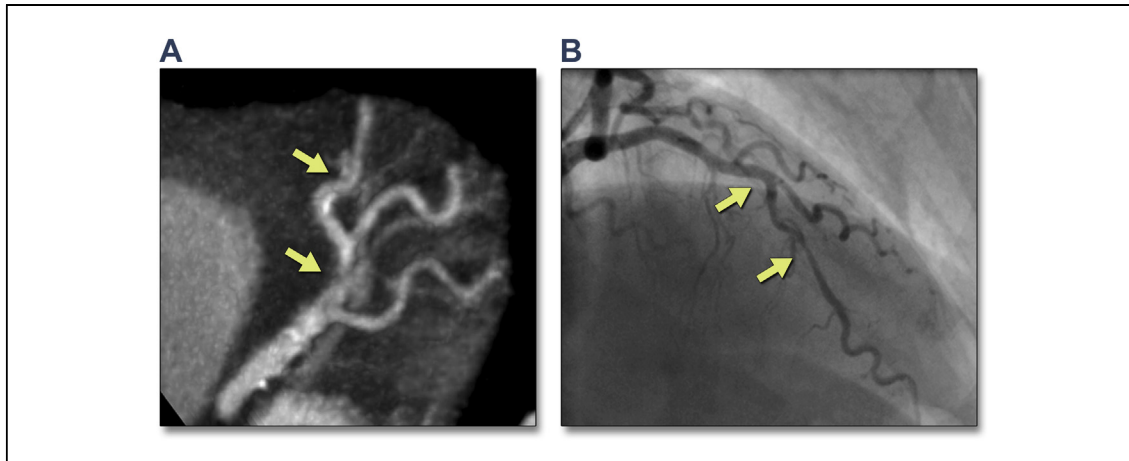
Cardiac Veins Affecting Coronary Arterial Lumen Assessment by CTA
